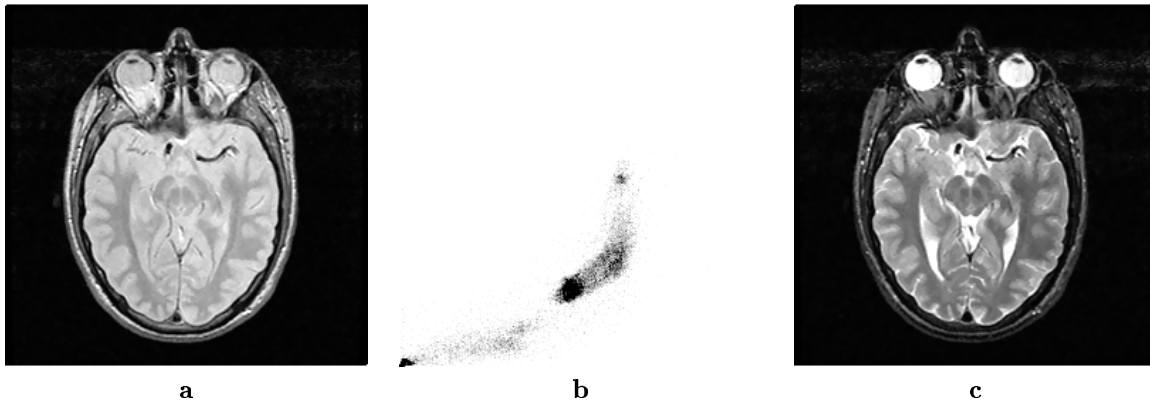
Spin-echo MR image pair (an early echo is shown on the left, a late echo on the right). In the middle the two dimensional intensity distribution is given
